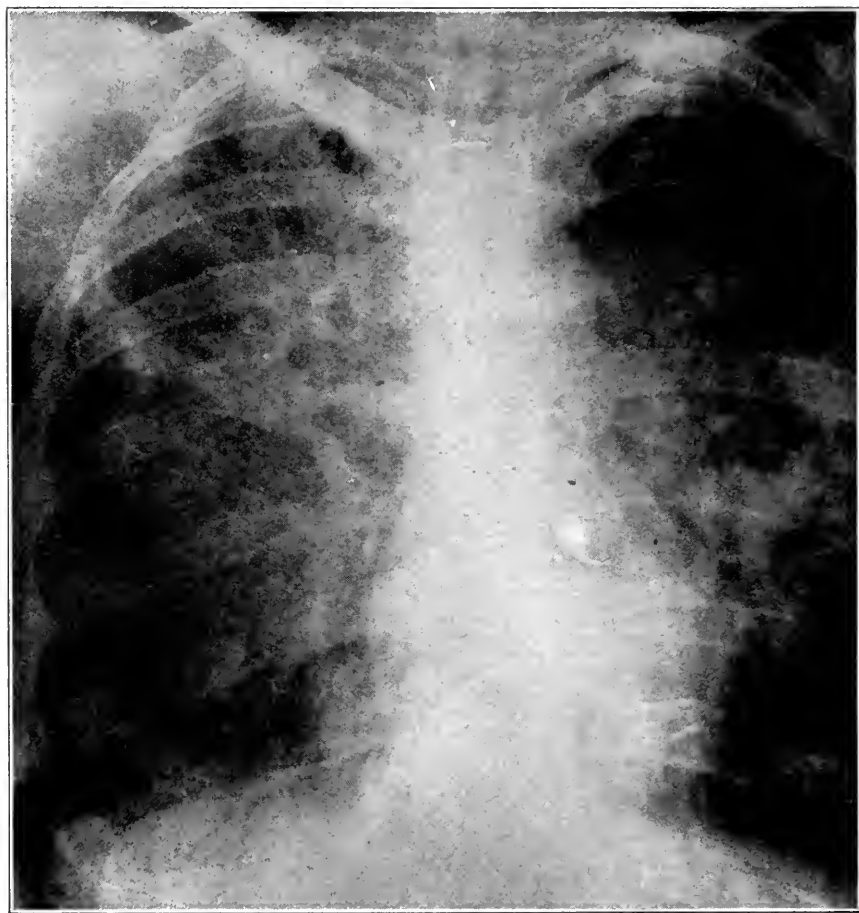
Case 225. Roentgenogram of the lungs in an advanced case with large multiple cavitation, not typical and in earlier stages more difficult to diagnose.
